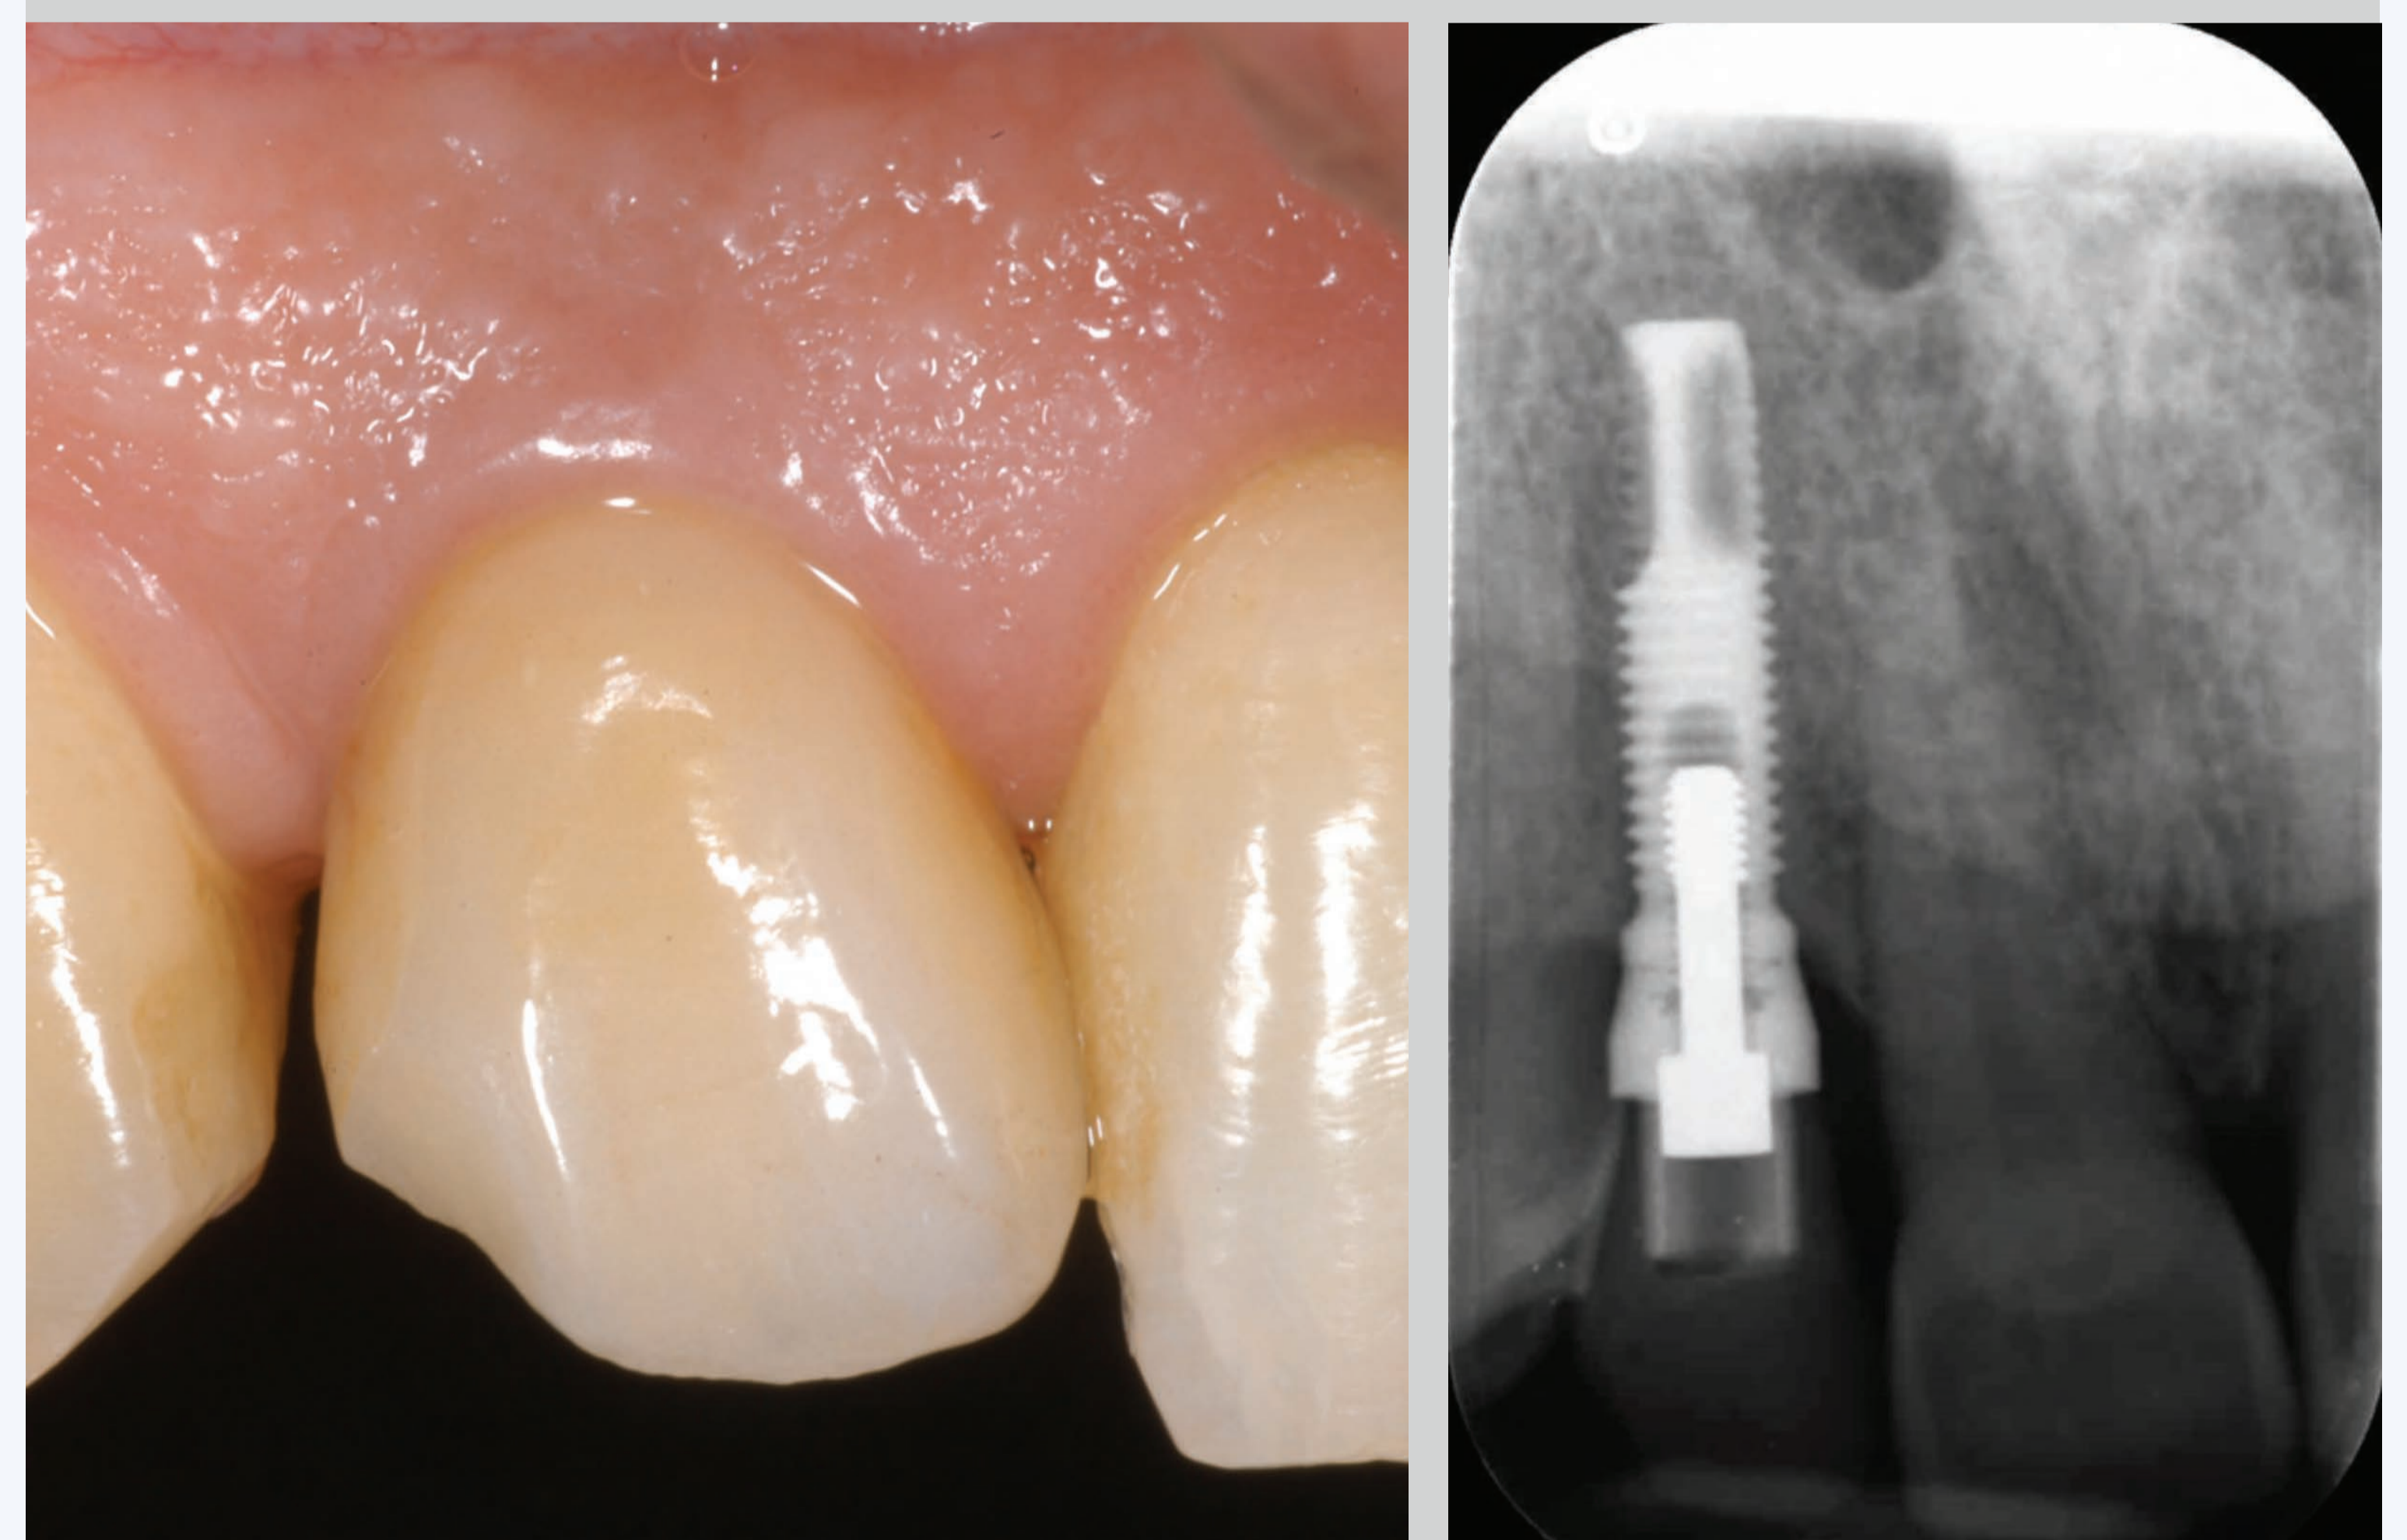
Final prosthesis delivery 3 months after implant placement (left) and radiograph at 12 years after implant placement (right). Note the perfect integration and no marginal bone loss.
